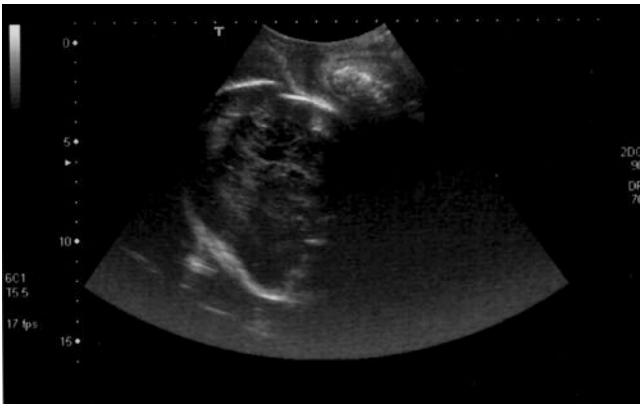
Translabial sagittal ultrasonographic section in the second stage of labor: the fetal head is in occiput posterior position, in upward direction. The image shows the physiologic molding and the caput succedaneum. A molding associated to the caput succedaneum represents a reason of vacuum application failure, during vaginal operative delivery
